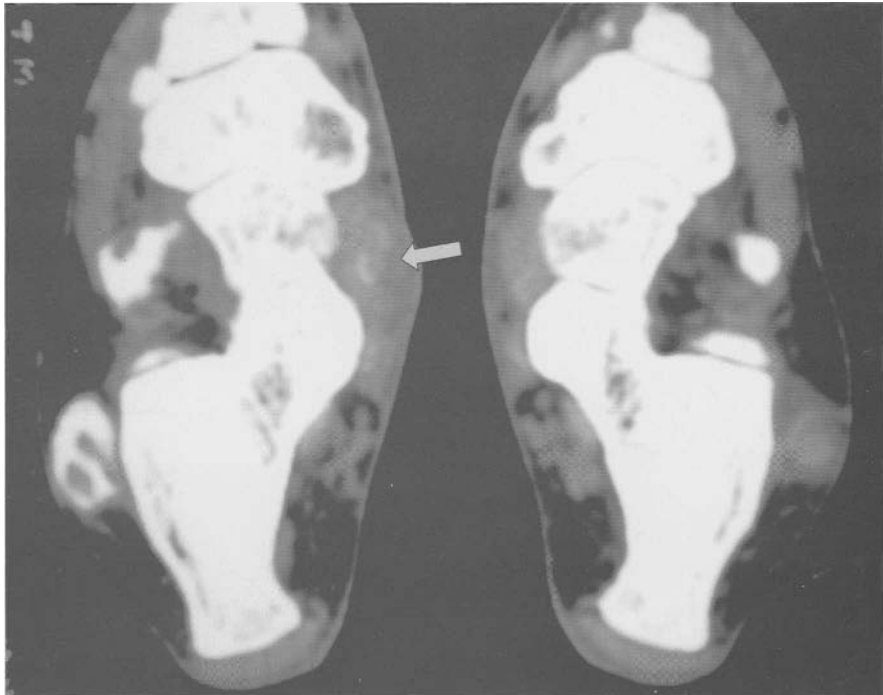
CT tenography. Long fibularis tendon ruptured (empty sheath). (Arrow).
